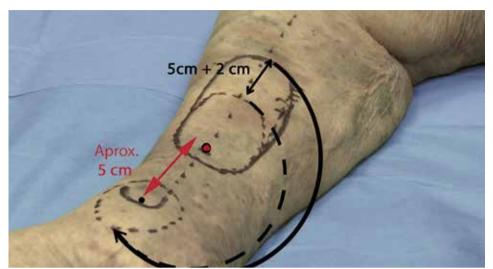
The centre of the defect is established first. Once the emergence point of the distal perforator (red point) has been localized by Doppler examination, its distance to the central aspect of the defect is measured (5 cm in this case). The propeller flap is outlined measuring the arc of rotation (dotted arrow). The flap's rotation or probably a minor displacement of the perforator artery has to be considered, and so it is advisable to add 2cm more to the proximal part of the flap length (5cm+2 cm).
